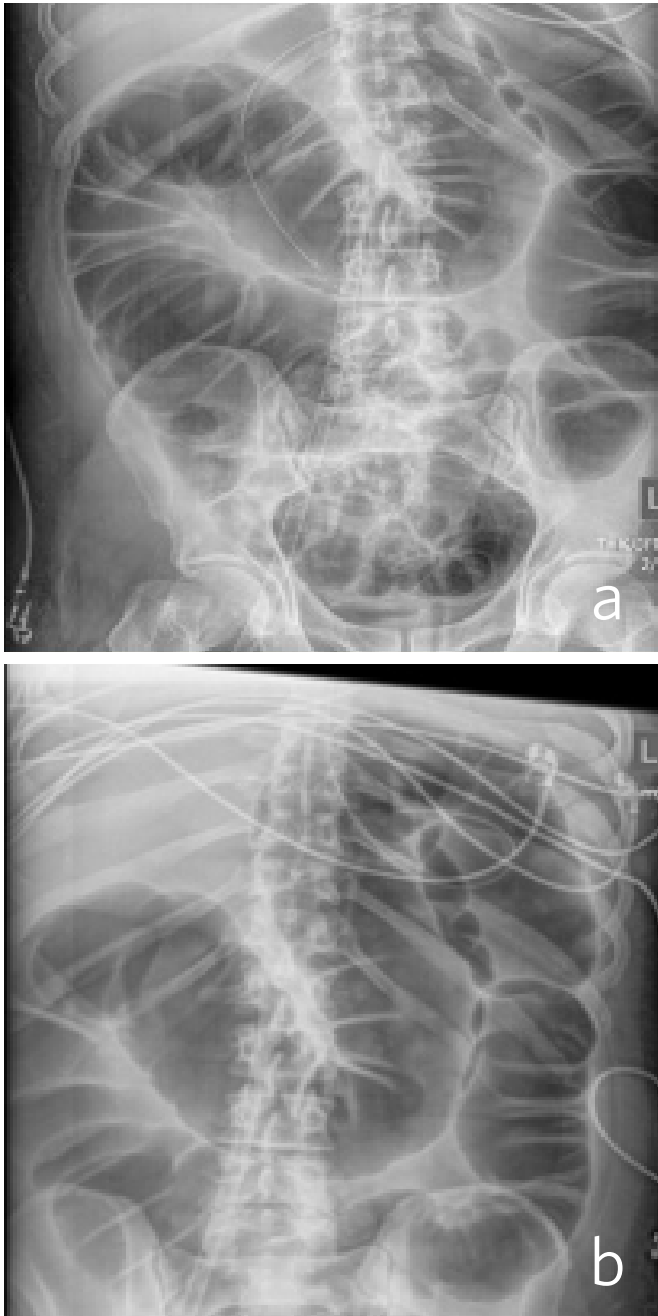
Case 2 CT imaging (a) abdominal X-ray showing generalized colonic distension; (b) abdominal X-ray showing progressive colonic distension; (c) abdominal X-ray showing resolution of colonic distension
